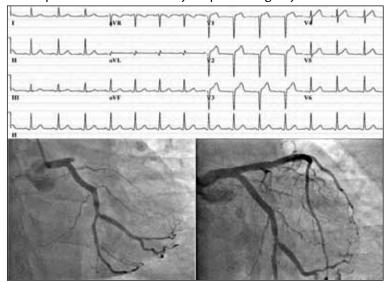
Case patient's echocardiogram, preprocedural angiogram, and final angiogram.
